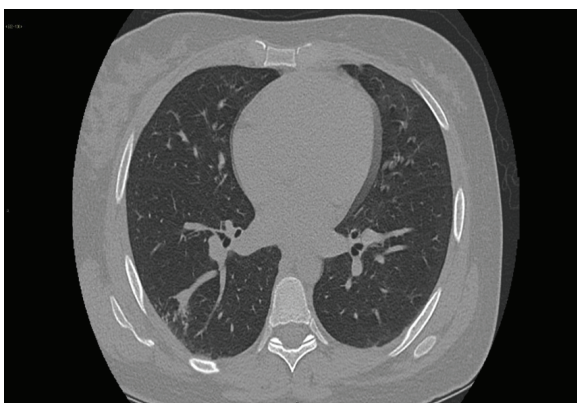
25 weeks' gestation. Chest CT showed prominent vein and aneurysmal component.
